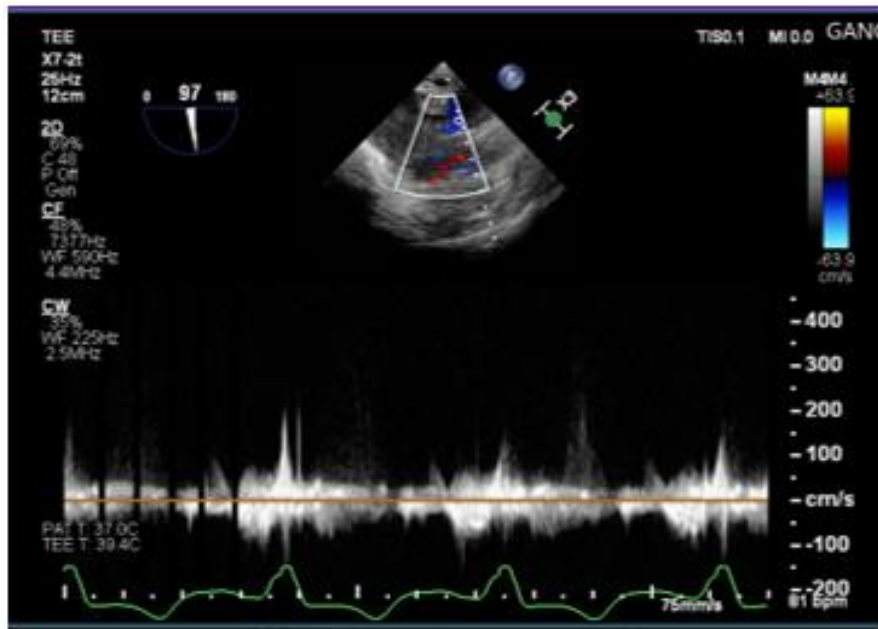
Post-aneurysmectomy TEE demonstrating marked qualitative reduction in functional MR with a faint and incomplete CW Doppler regurgitant signal
